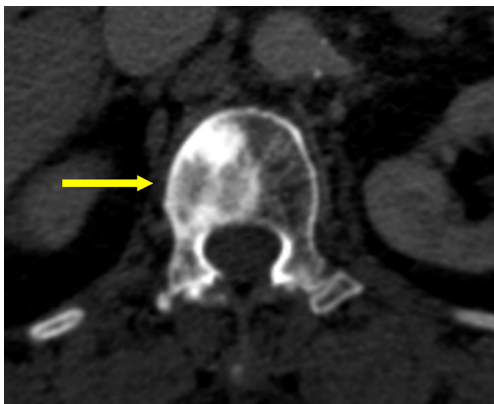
An axial CT imaging showing an inhomogeneous sclerotic lesion in the vertebral body (arrow), concerning for osteoblastic metastasis. Courtesy of Dr. Kantheera Leesmidt. CT, computed tomography.
